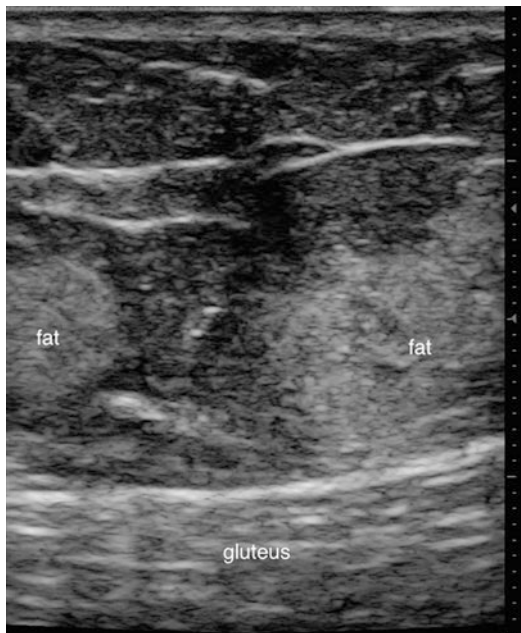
Grayscale ultrasound image of gluteal region. Hyperechoic deposits of fat grafts obscure the normal hyperechoic fat of the buttock region
